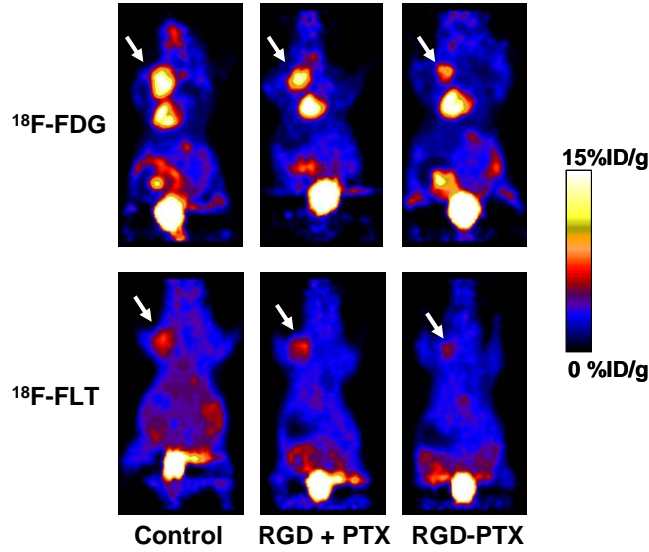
^{18}F -FDG/PET and ^{18}F -FLT/PET imaging showed that the tumor uptake follows the order of control > RGD + PTX > RGD-PTX, indicating the effectiveness of the RGD-PTX conjugate over PTX alone in terms of reducing the tumor metabolism (^{18}F -FDG/PET) and tumor proliferation (^{18}F -FLT/PET). Arrows indicate tumors in all cases.
